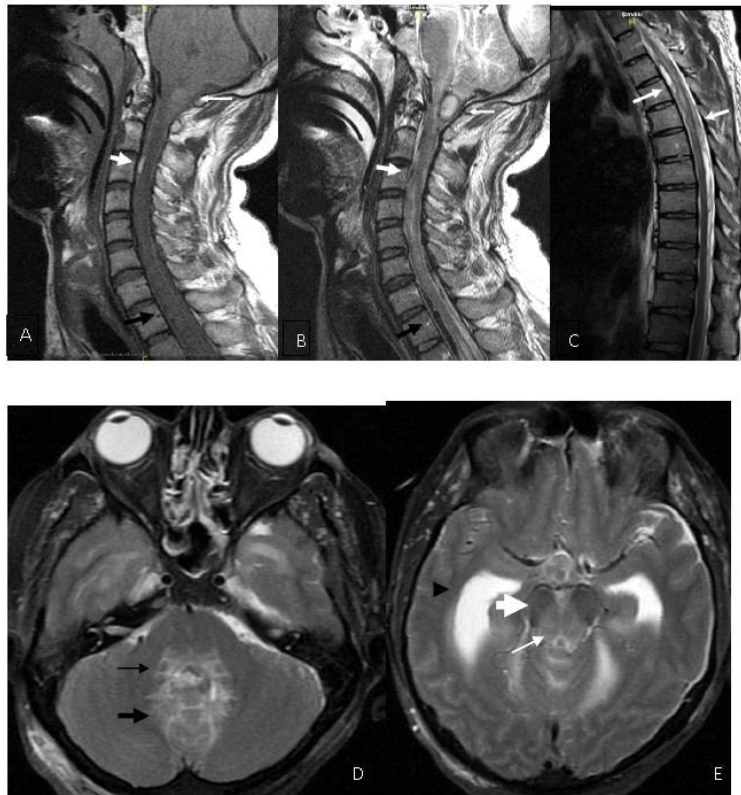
MR images show dural soft tissue masses, wrapping around the spinal cord at the cervical and thoracic levels. A. Sagittal T1 weighted MR image (cervical level), B. Sagittal T1 weighted MR image (thoracic level), C. Sagittal T2 weighted MR image (thoracic level), D. Axial T2 weighted MR image (pons level), E. Axial T2 weighted MR image (mesencephalon level). Spinal cord is hyperintense at the cervical and upper thoracic level. Dural masses are hyperintense on T1-weighted images and hypo- and hyperintense on T2-weighted images depending on the stage of the hemorrhage (white and black arrows). There is a hematoma at the craniocervical junction with minimal cord compression (white thin arrow). Symmetrical hyperintensity of the midbrain (thick white arrow), pons (black arrow), periaqueductal gray matter (white arrow) and cerebellum (thick black arrow) is well seen on the T2 weighted scan, these findings are compatible with brainstem involvement. Hydrocephalus is present (arrowhead).
